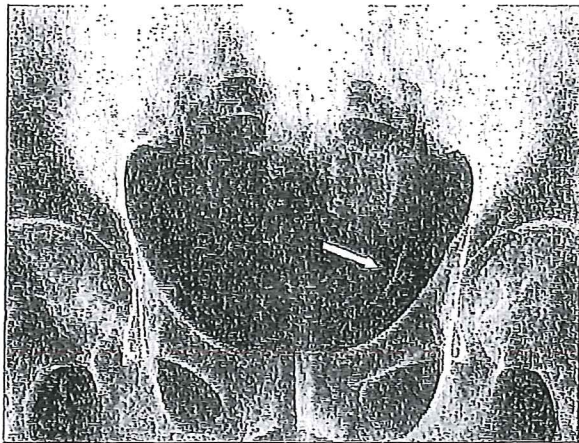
Plain radiograph of the abdomen demonstrates a fractured long limb (arrow) that embolized to the left iliac vein.
